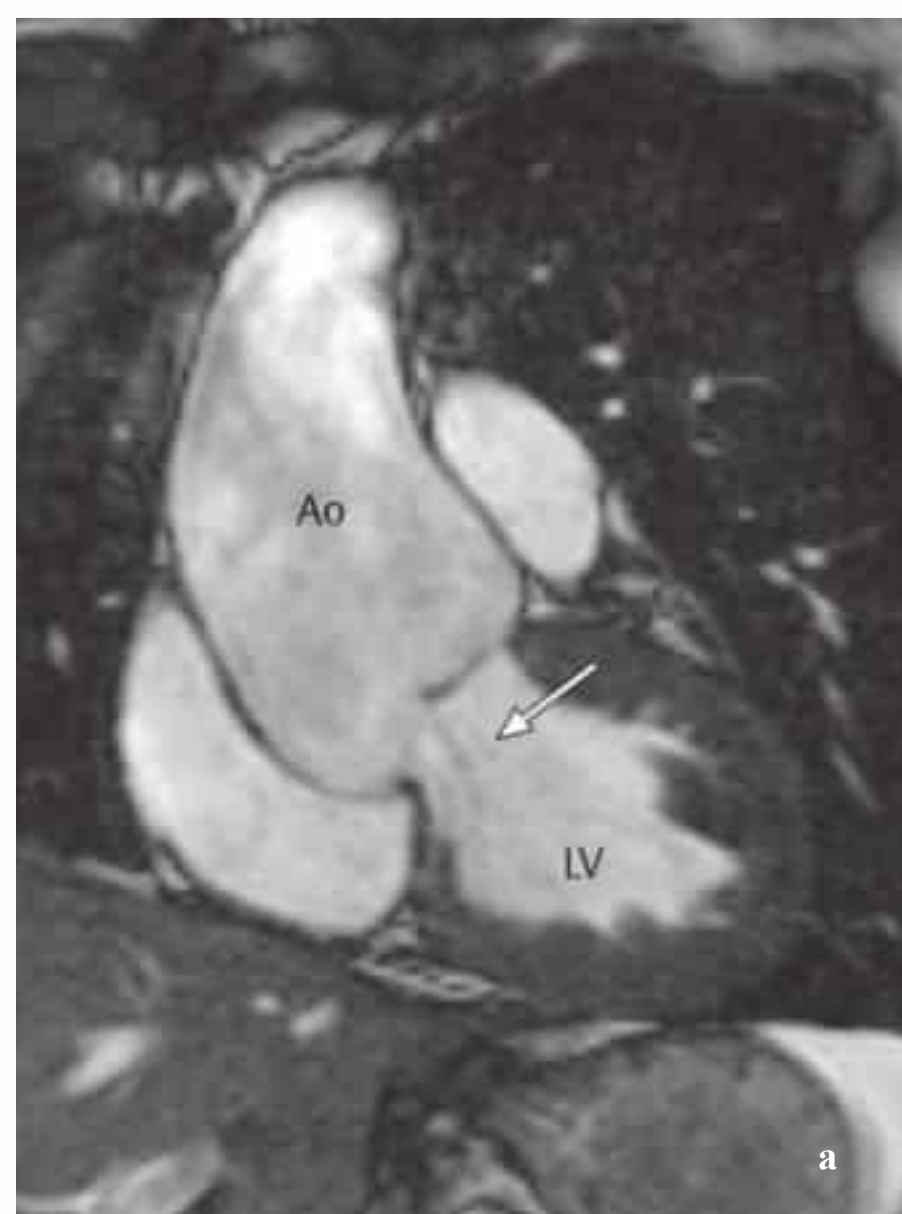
a–d MRI findings in aortic insufficiency.
